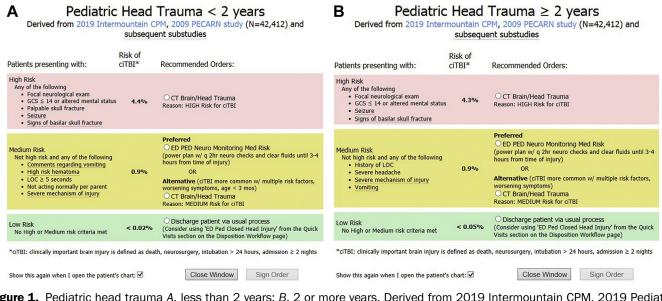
Pediatric head trauma *A*, less than 2 years; *B*, 2 or more years. Derived from 2019 Intermountain CPM, 2019 Pediatric Emergency Care Applied Research Network study (N=42,412) and subsequent substudies. ciTBI, clinically important traumatic brain injury (defined as death, neurosurgery, intubation > 24 hours, admission \geq 2 nights); *CPM*, care process model; *CT*, computed tomography; *GCS*, Glasgow Coma scale/score; *LOC*, loss of consciousness; *PECARN*, Pediatric Emergency Care Applied Research Network; *PED*, pediatric ED.
